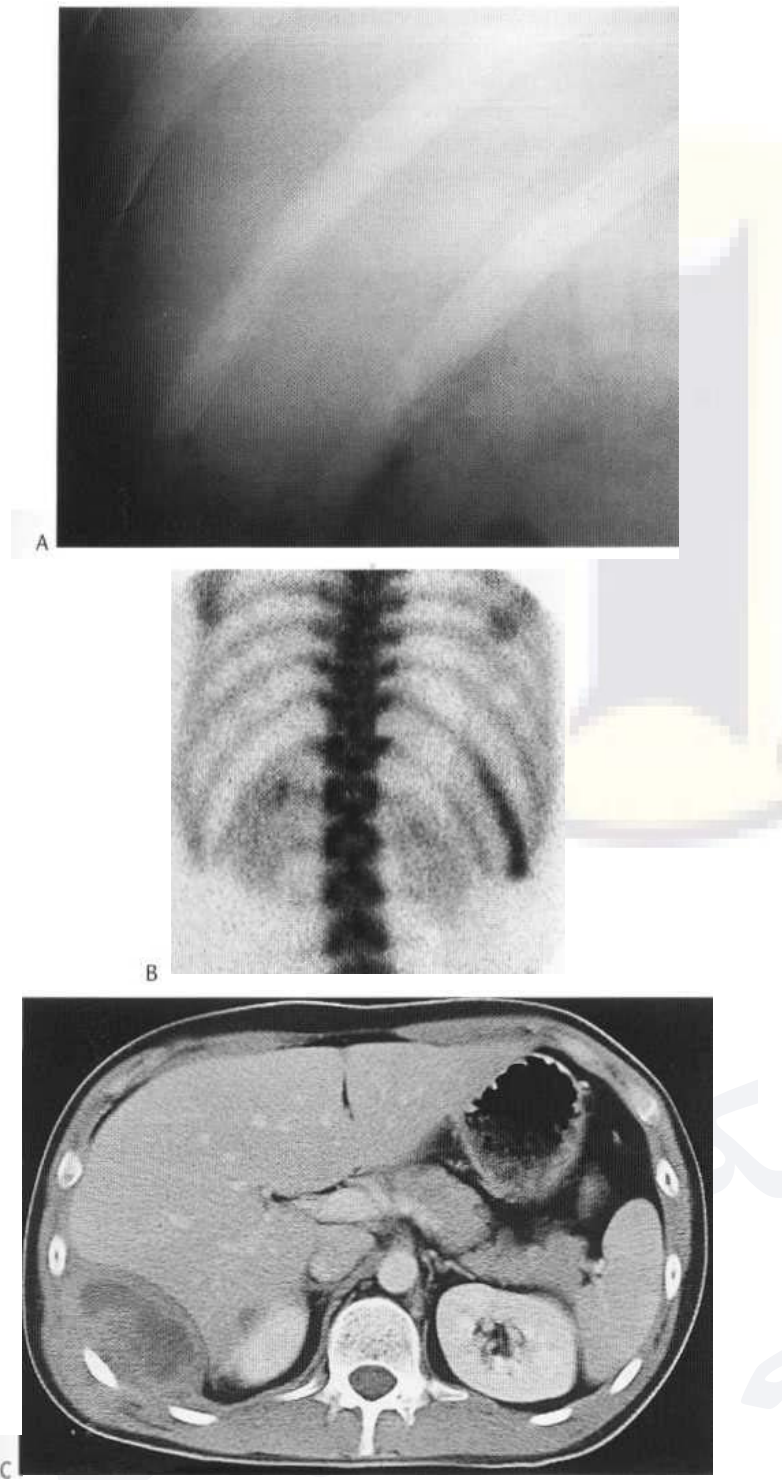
Ewing's sarcoma of a lower rib. The conventional radiograph (A) shows a long moth-eaten lesion of the eleventh right rib which demonstrates prominent increased scintigraphic activity on the posterior bone scan (B). The extent of the associated soft-tissue mass, however, is best demonstrated on the CT (C) of the upper abdomen (dynamic enhanced scan).
